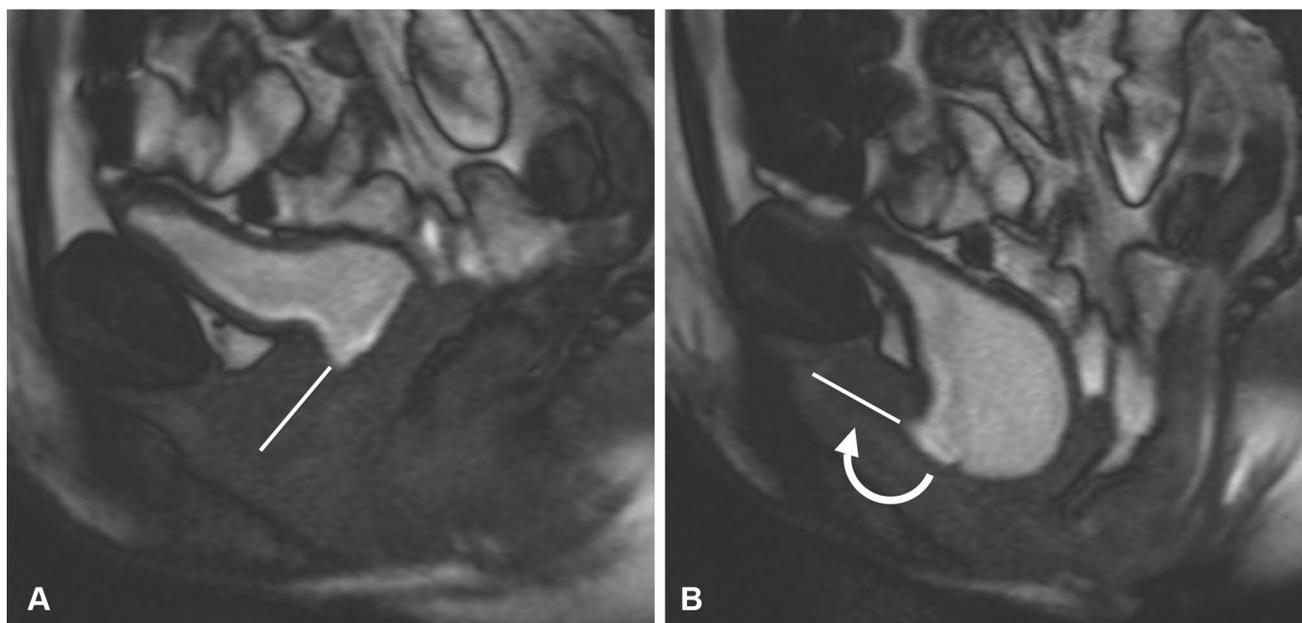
Moderate-severe cystocele with urethral hypermobility. Sagittal T2-weighted images at rest (a) and during Valsalva (b) demonstrates descent of the bladder and hypermobility of the urethra (white line), rotating anteriorly more than 30 degrees (curved arrow)
